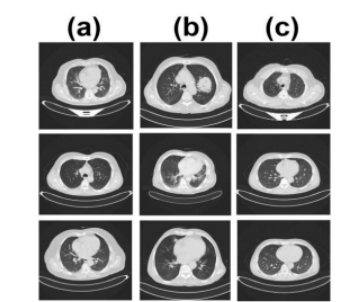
Examples of the CT images a) Benign, b) Malignant, and c) Normal.
